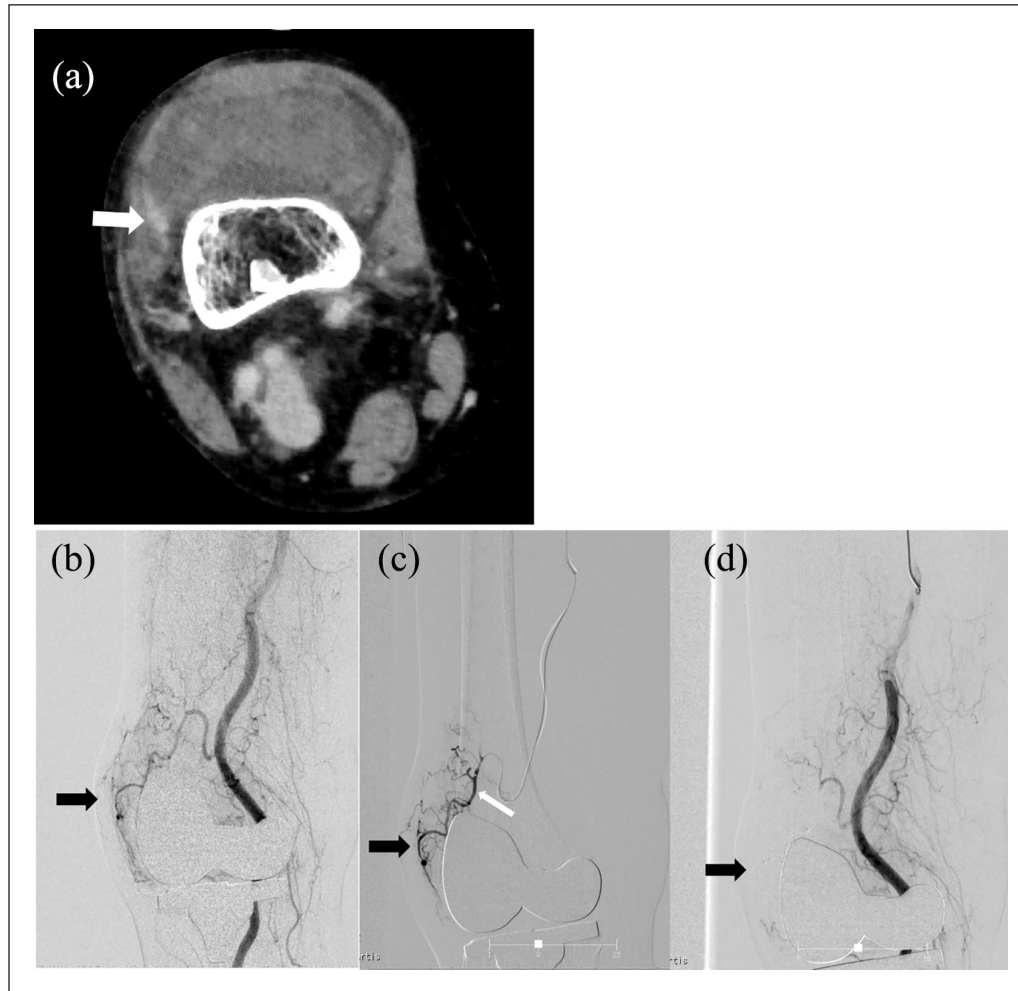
(a) A contrast-enhanced computed tomography (CT) shows joint effusion and prominent synovial enhancement (white arrow), and suspected hyperemic synovium in superior lateral suprapatellar pouch. (b) A digital subtraction angiography shows hyperemic blush in the superior lateral aspect of the knee (black arrow). (c) Selective catheterization reveals abnormal hyperemic blush supplied from branches of the superior lateral genicular artery (white arrow). (d) After embolizing selectively with a suspension of N-butyl-2-cyanoacrylate (NBCA) and Lipiodol, subtotal devascularization of branches from superior lateral genicular artery is observed.
